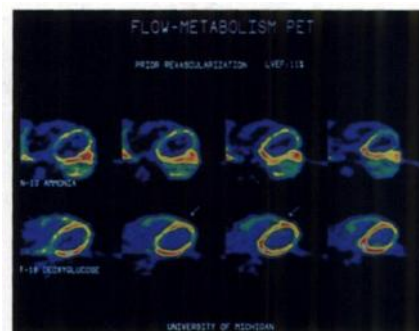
Selected transaxial images of ^{13}N -ammonia (above) and FDG (below) obtained in a patient being considered for cardiac transplantation. The images are displayed from the mid-ventricular level on the left towards the diaphragmatic surface on the right. The heart is significantly dilated. Resting perfusion was inhomogeneous and particularly reduced in the septum. FDG retention in the heart was, in comparison, relatively well preserved, especially in the septum (arrow) indicating viable, but compromised myocardium. The patient underwent surgical revascularization with improvement of global left ventricular function and marked improvement of symptoms.
